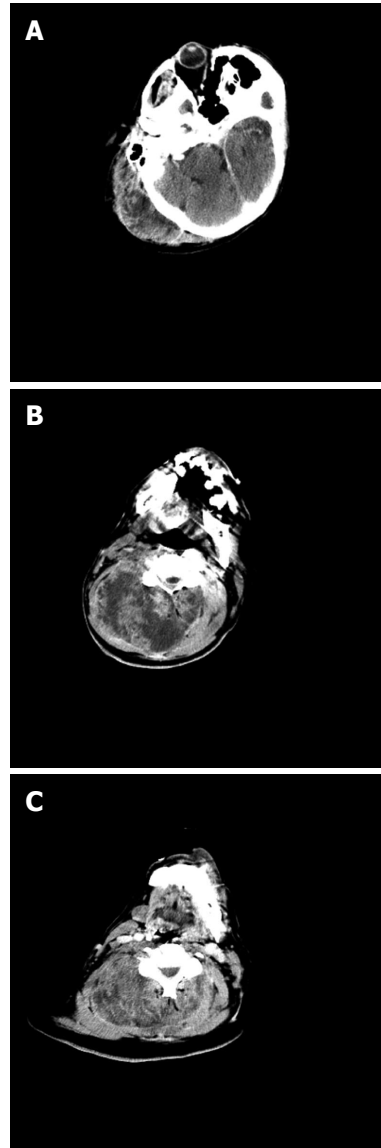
Cervical contrast-enhancement spine computed tomography. A: Occipital axial-scan with evidence of a right mass lesion in the pericranial soft tissues; B: Axial-scan passing through the body of C3. Note the almost complete replacement of the paravertebral muscles with the tumor; C: Axial-scan passing through C5.
